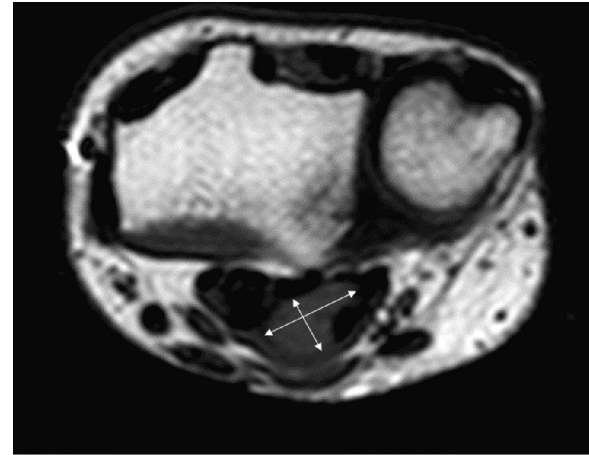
Axial T1 MRI at level of distal radioulnar joint in clenched fist position.
